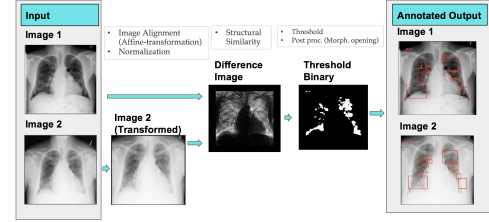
Identification of Structural Differences in X-Rays
